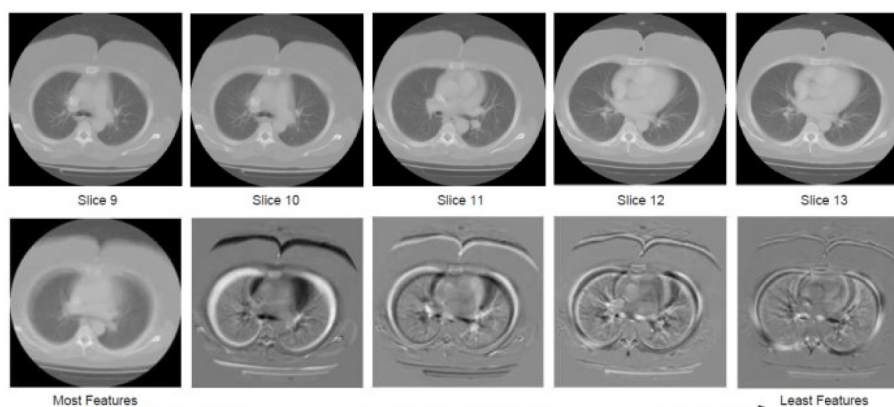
Images from Computed Tomography reduced by PCA, [1].
